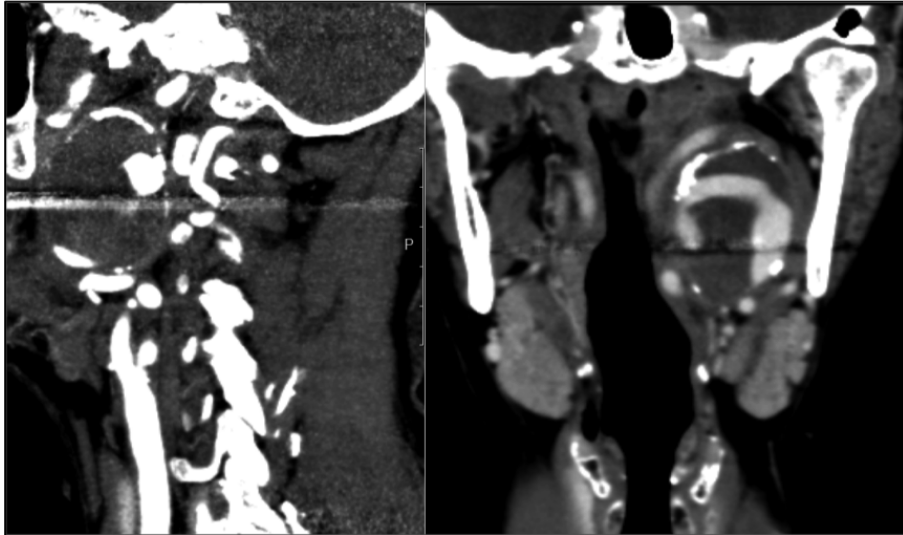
Female patient with history of SAH, presenting with symptoms of voice alterations and dysphagia, CTA showed a giant ECAA in the left ICA.
